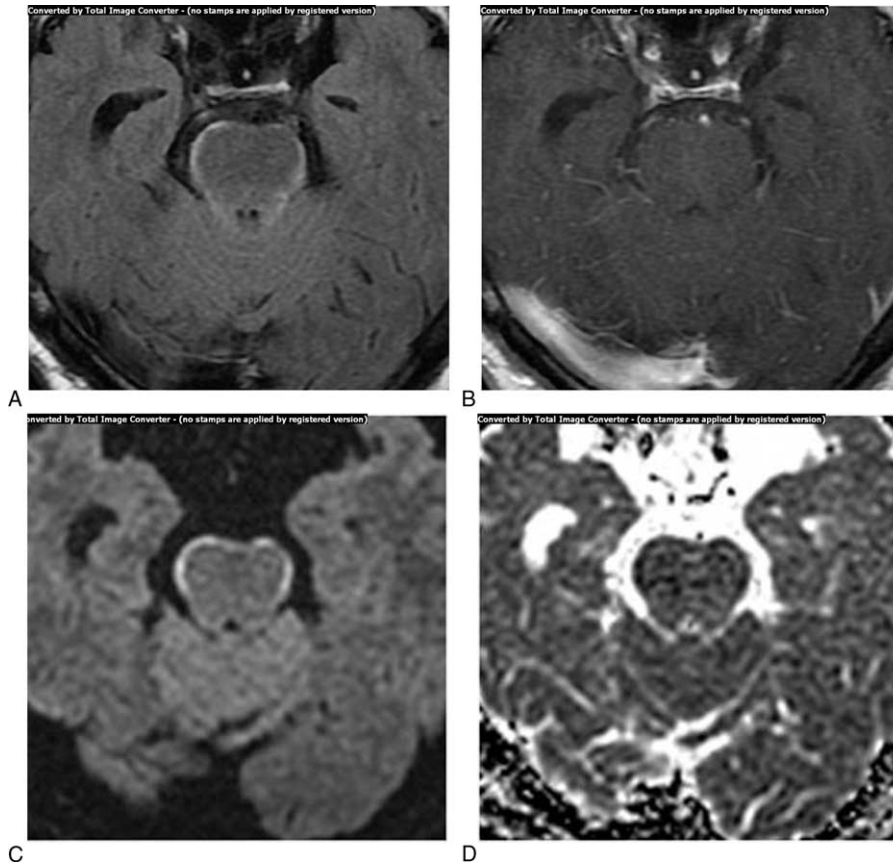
Case 1. A 75-year-old man with lung adenocarcinoma. (A) A T2-FLAIR (fluid-attenuated inversion recovery) image shows bilateral symmetrical curvilinear high signal intensity along the surface of the pons. (B) A contrast-enhanced T1-weighted image reveals no enhancement in the lesion. (C) DWI. (D) An ADC map shows symmetrical curvilinear cytotoxic edema along the pons.
